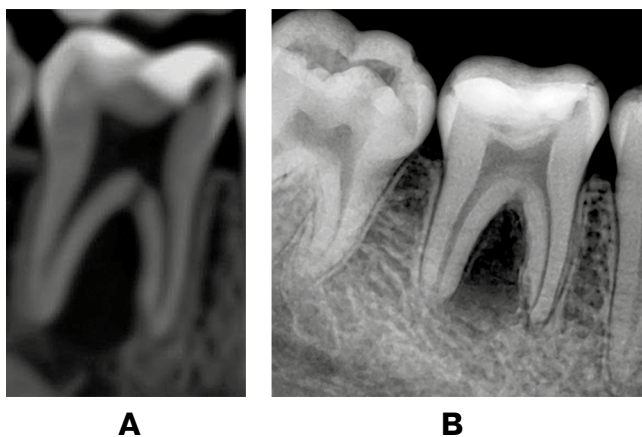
Isolated furcation bone and apical bone destruction in the furcation area of tooth # 46 on apical radiograph (A) and cone beam computed tomography (B) images
